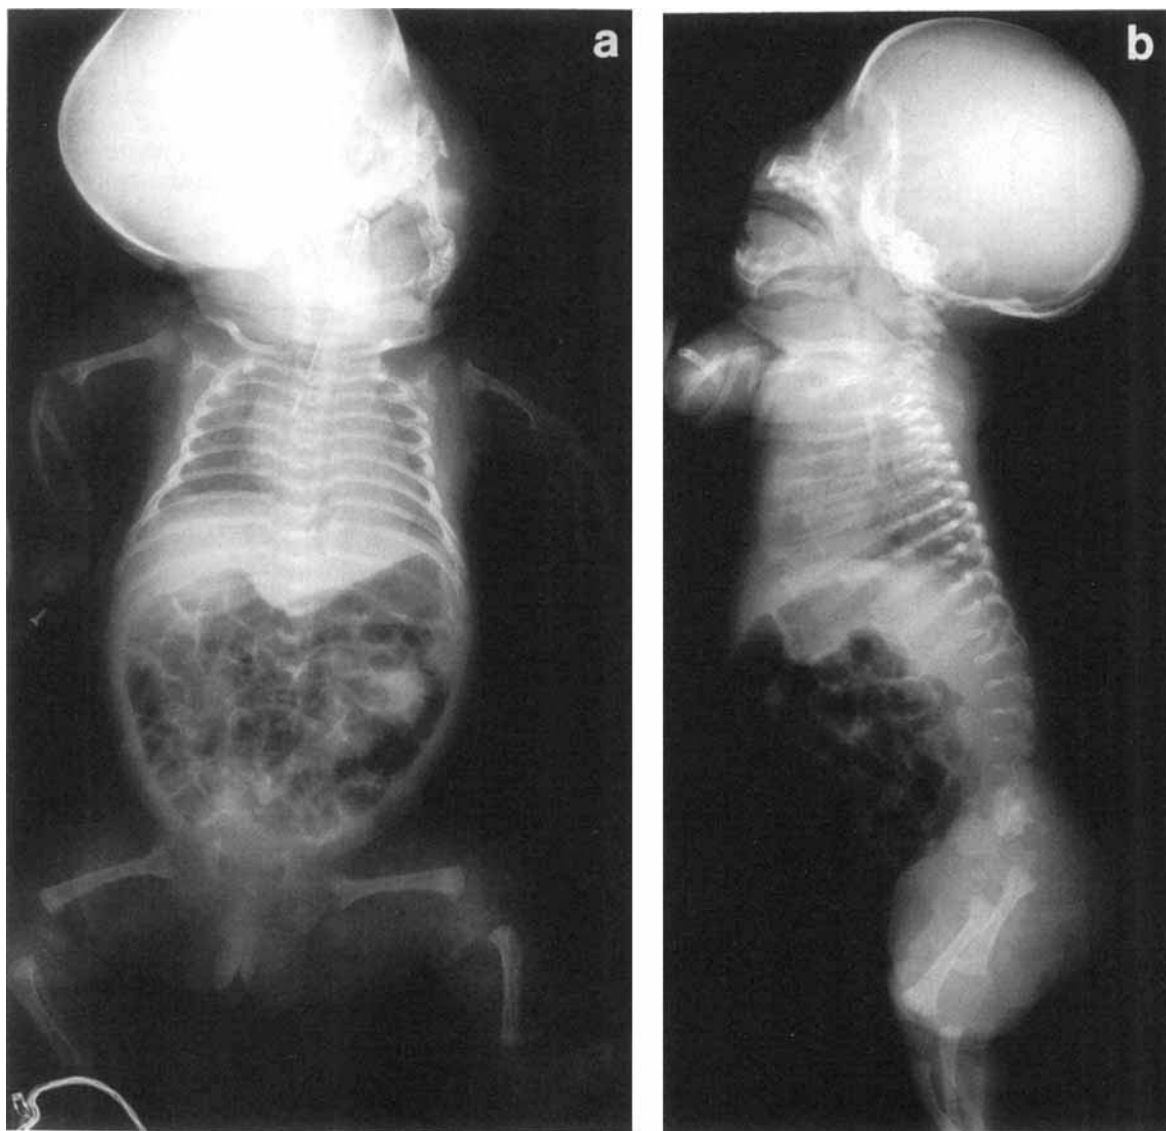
Skeletal radiographs. Note narrow thorax with thin ribs, rhizomelic shortness and overtubulation of the long bones (a), short skull base and severe platyspondyly (b), short and broad ilia with short greater sciatic notch and metaphyseal flaring of the femora (c), and deep intercondylar notches of the distal humerus, bowed humerus and Madelung-like deformity of the forearm (d).
